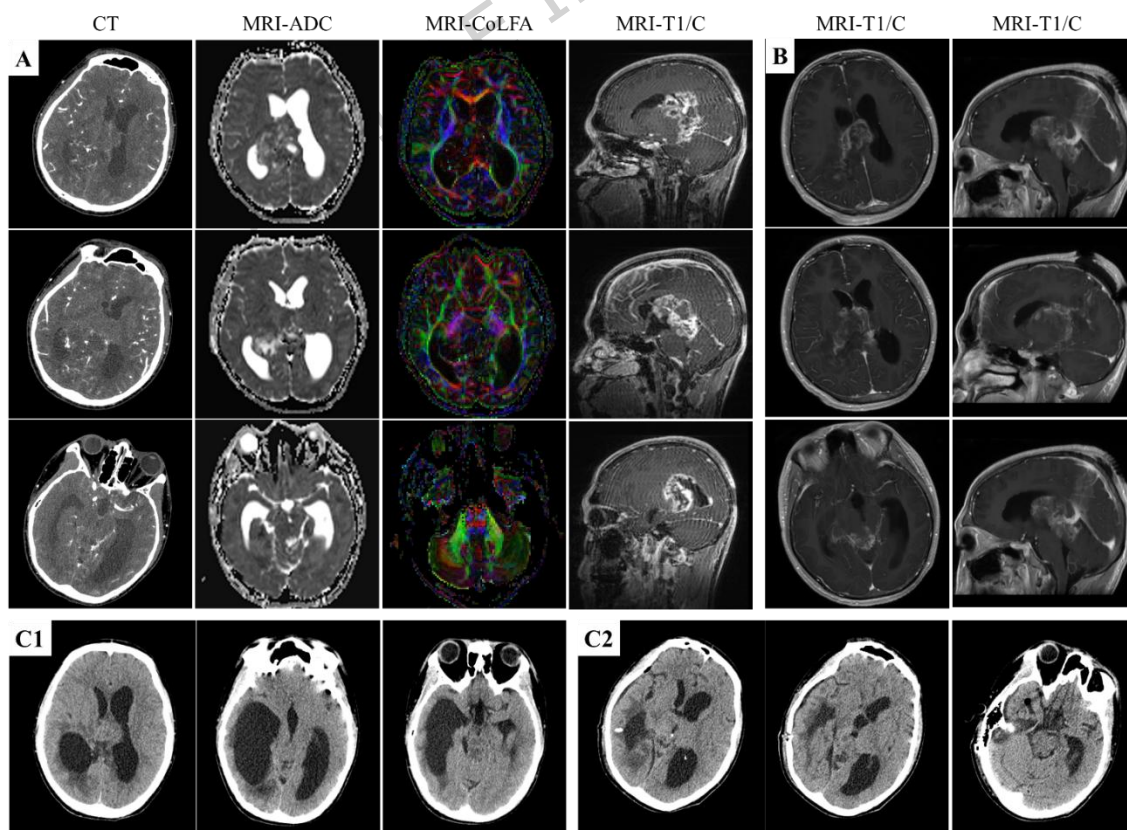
Radiology test of patient 1 before recurrent. A: Before surgery: CT and MRI scan were test. CT scan shows a mixed-density mass in the midline region of the brain, exhibiting cystic-solid features. High-density calcifications are visible within the lesion. The mass primarily involves the brainstem, third ventricle, posterior horn of the right lateral ventricle, septum pellucidum, and splenium of the corpus callosum. MRI scan by T1/C and ADC shows the largest cross-sectional area of the tumor measures approximately 5.4×5.7 cm, and there is supratentorial ventricular enlargement. B: 72 hours after surgery: MRI scan shows a patchy mixed-signal area in the surgical region, with localized uneven diffusion restriction. Contrast-enhanced imaging reveals multiple areas of enhancement along the lesion margins and adjacent brain tissue. Short T1 signal areas are seen in the bilateral ventricles, third ventricle, and some sulci of the right cerebral hemisphere. Mild dilation of the bilateral ventricles and third ventricle is also noted. C: Five months after the surgery, bilateral lateral ventricle effusion was found. C1: Before VP drainage surgery, the anterior horn of the right lateral ventricle is compressed and narrowed, while the temporal horn of the right lateral ventricle and the posterior horns of both lateral ventricles are markedly dilated. The midline structures are slightly shifted to the left, and there is severe supratentorial hydrocephalus. C2: After VP drainage surgery, the hydrocephalus was significantly relieved.
